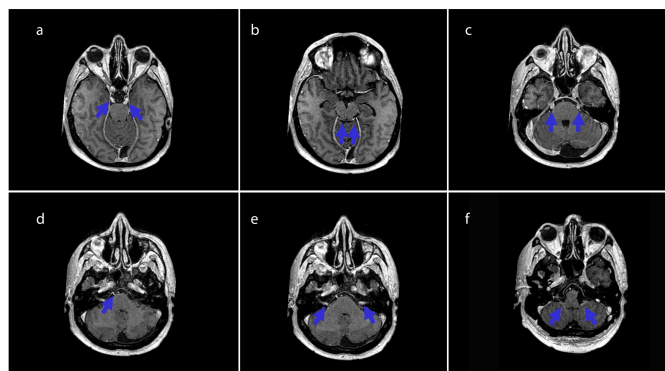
Contrast-enhanced thin-slice (1 mm) axial T1-weighted images demonstrate linear enhancement of bilateral oculomotor (III) (a), trochlear (IV) (b), trigeminal (V) (c), right abducens (VI) (d), bilateral facial–vestibulocochlear (VII–VIII) (e), and glossopharyngeal–vagal (IX–X) (f) nerves (arrows).
